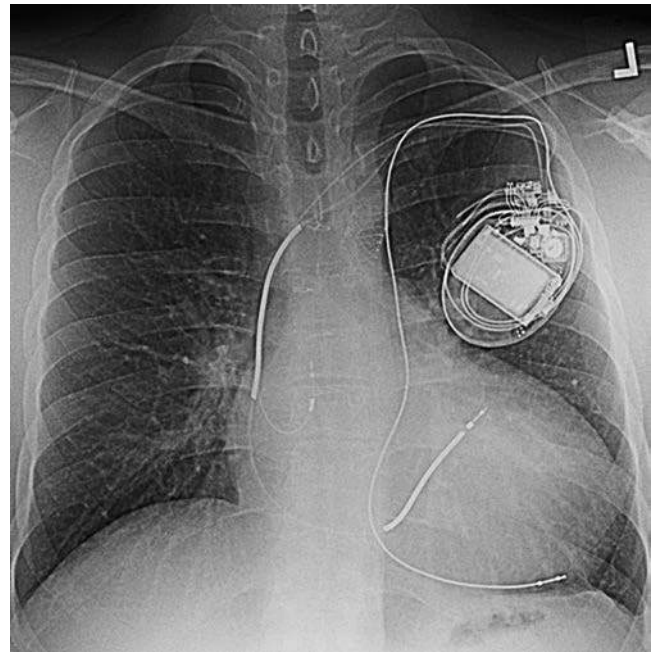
Chest x-ray from a 32-year-old with congenitally corrected transposition of the great arteries (L-TGA), complete heart block, ventricular tachycardia, and a failing systemic ("right") ventricle. A transvenous implantable cardioverter defibrillator (ICD) system with leads for chronic resynchronization pacing is in place. The atrial lead and the ICD shock/pace lead were positioned from the left subclavian vein in the usual fashion via the superior vena cava to the right atrium and subpulmonary ("left") ventricle. There was ostial atresia of the coronary sinus, which confounded positioning of the second ventricular pacing lead into the coronary venous system. Fortunately, a small persistent left superior vena cava was identified draining to the coronary sinus, which allowed effective positioning for the systemic ("right") ventricular pacing lead.
